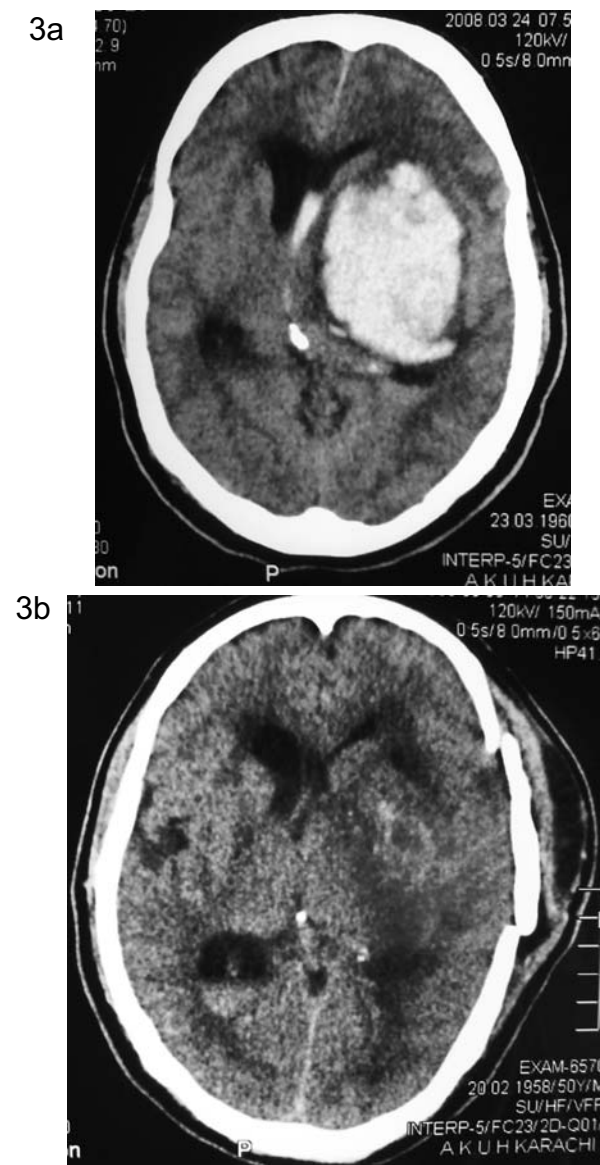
CT Brain showing large left basal ganglia bleed with mass effect and intraventricular spillage of blood. Surgery offered as a life saving procedure after patient developed signs of herniation. a - Preop scan, b - post op scan.
